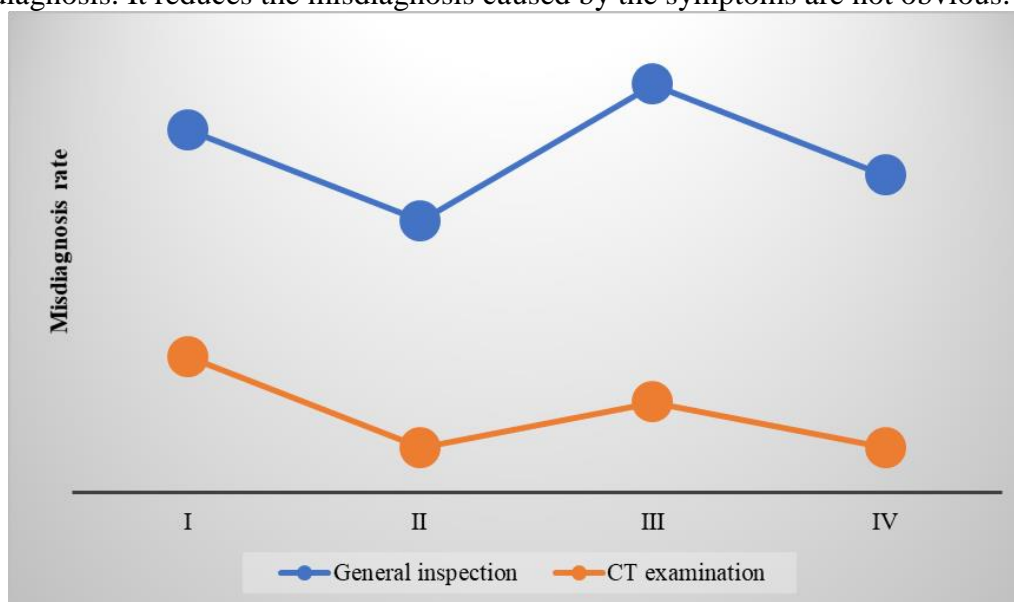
The change of misdiagnosis rate of vitamin B₁ deficiency encephalopathy before and after using CT technology
